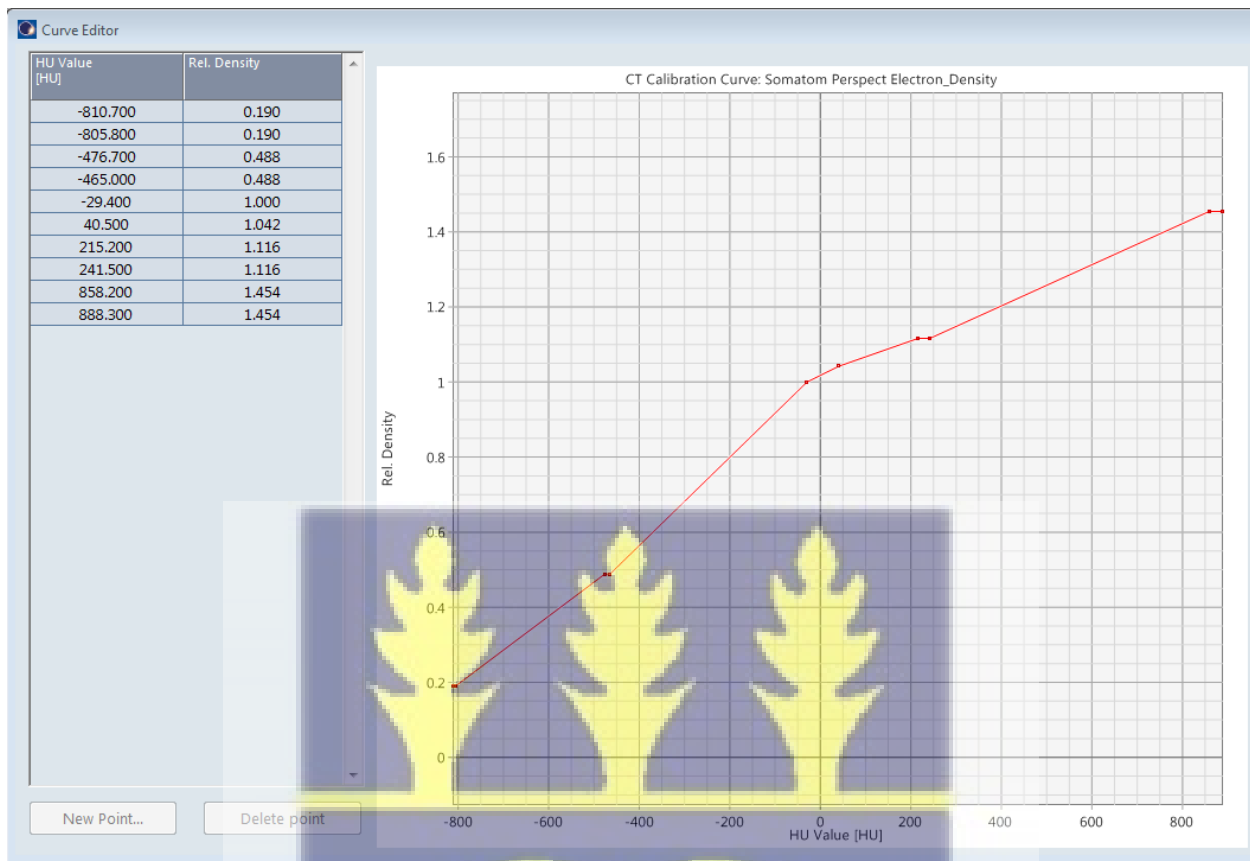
The relative electron density (RED) curve of the Siemens Somatom Perspective CT scanner incorporated in the Eclipse TPS.
